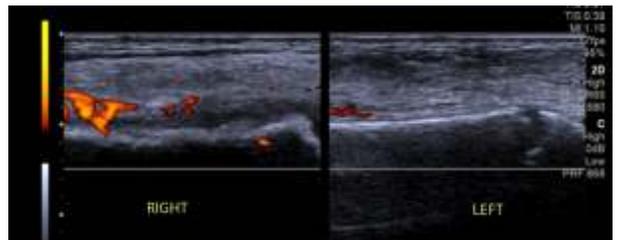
Six weeks later, follow-up ultrasound images of both right and left distal tibia showed irregular bone margins on the affected side(right) and smooth bone on the left distal tibia, which is normal.
